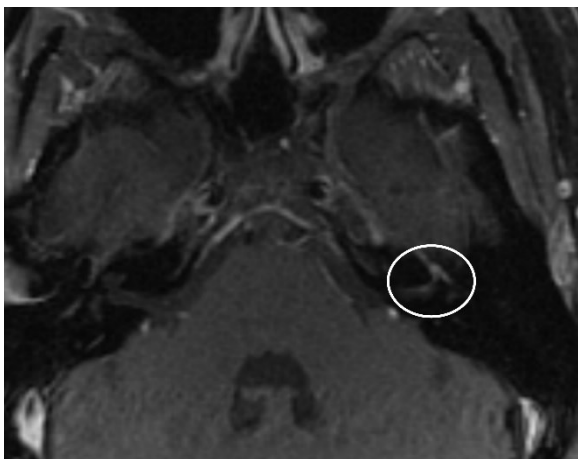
45-year-old female with Bell's palsy. Contrast-enhanced fat-suppressed T1-weighted image shows an enhancement (within circle) of the facial nerve (meatal, labyrinthine, and tympanic segments).
